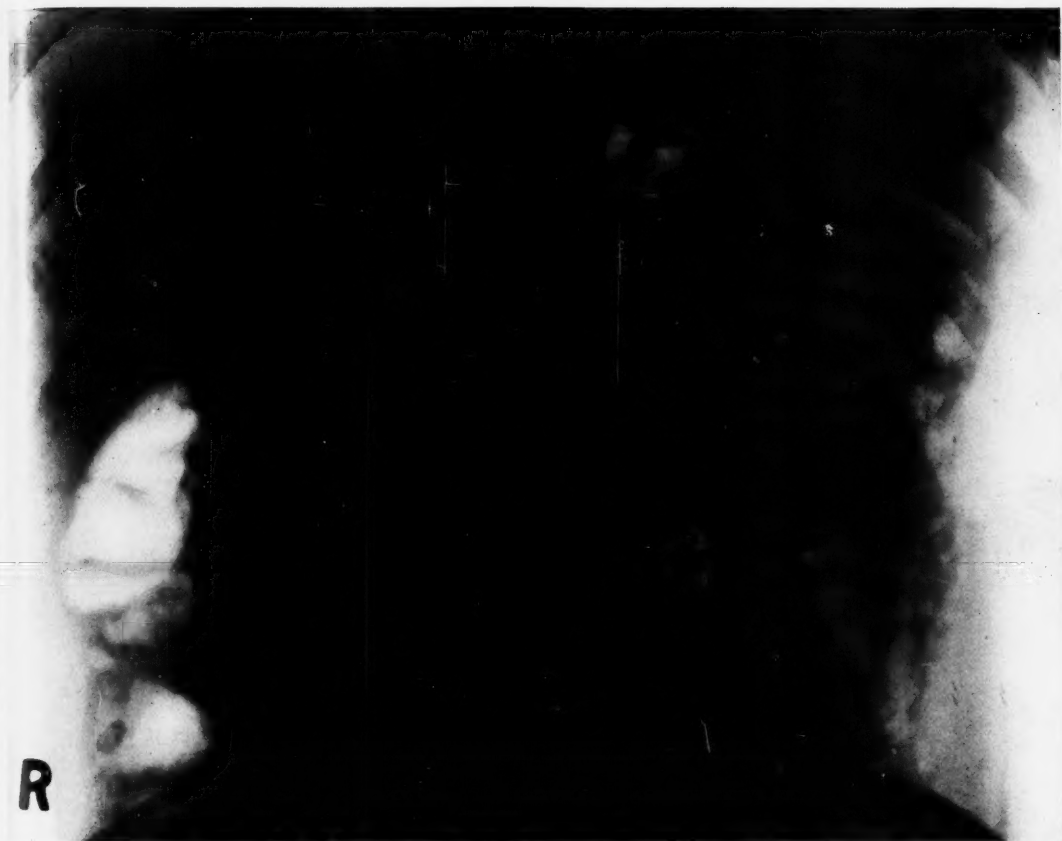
Case 1. X-Ray taken after perirenal insufflation showing left adrenal tumour outlined by air
